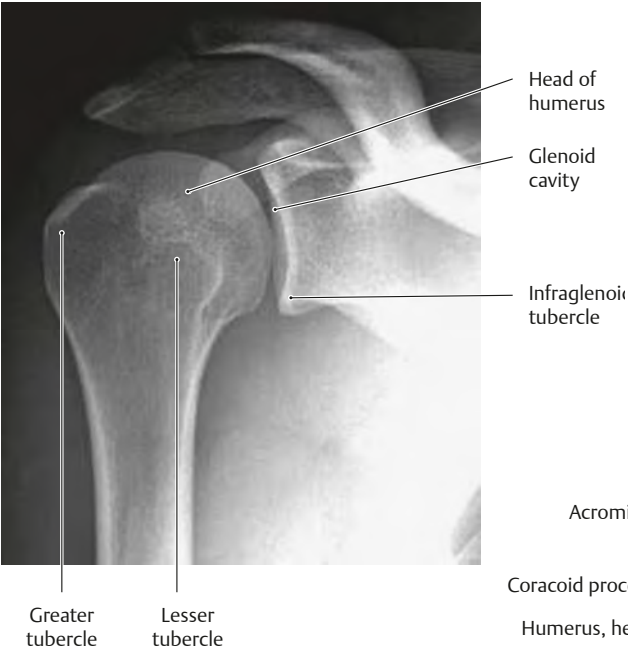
Radiograph of the right shoulder
